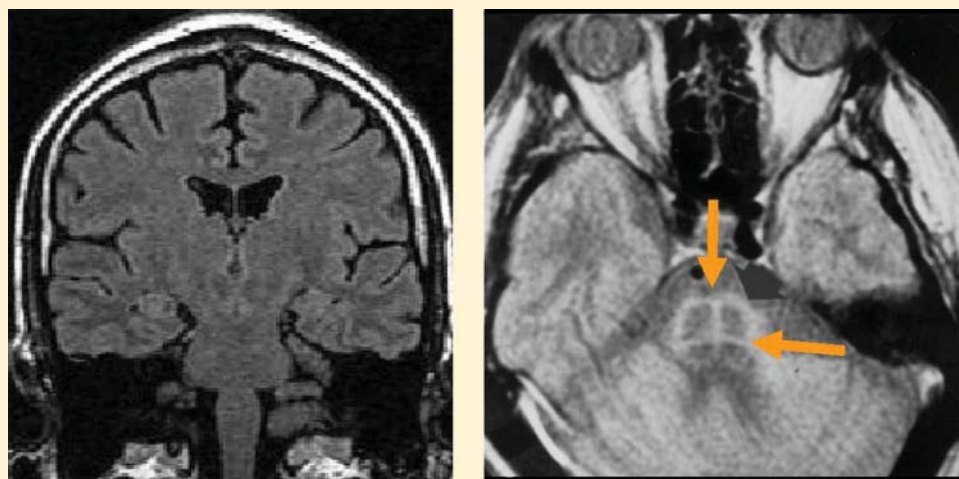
Magnetic resonance imaging in a patient with Shy-Drager (left) is normal; a “hot cross buns” sign may be evident in patients with multiple-system atrophy (right).
